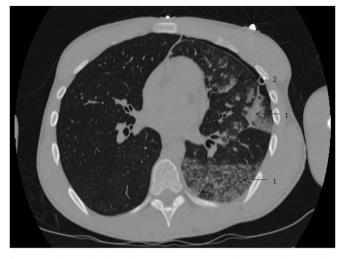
Axial CT of the chest showing re-expansion pulmonary edema with ipsilateral ground-glass opacities (black arrow 1) and septal thickening (black arrow 2).
